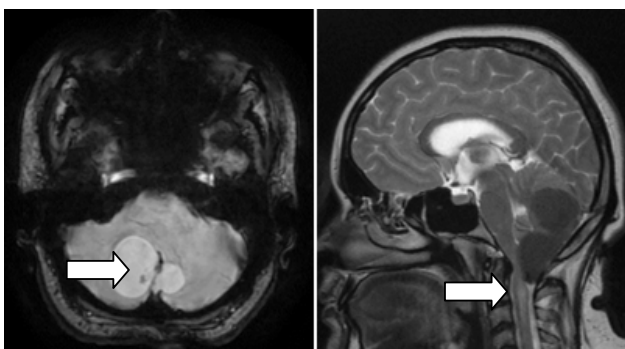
Magnetic resonance imaging - Gradient sequence (GRE e SWAN) showing focal area of blooming (white arrow) in the lesion and Saggital T2 weighted image shows cervical cord edema. E. DWI sequence shows no diffusion restriction.
